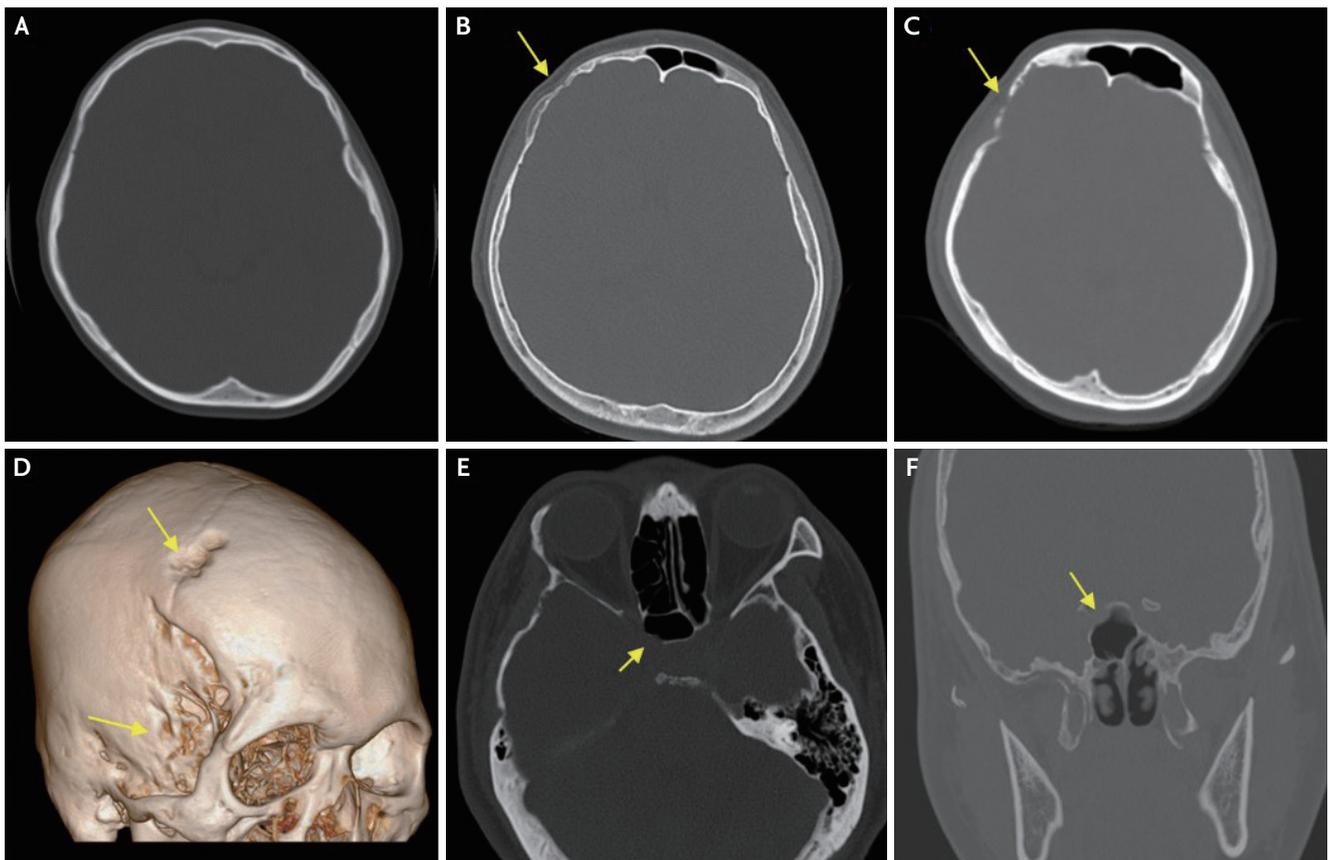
Serial brain CT scan, 3D reconstruction, and OMU CT scan. Serial brain CT scans over a period of more than 10 years revealed progressive cortical thinning of the skull, especially the right frontal bone, right temporal bone and body, and lesser wing and pterygoid plate of the right sphenoid bone. Brain CT performed in 2001 (A) when he fell showed no evidence of cortical thinning, but his CT scan performed in 2007 (B) when he was admitted for bacterial meningitis showed mild erosion of the right frontal bone (yellow arrow). In 2018, the bony destruction had progressed, and extensive cortical thinning (yellow arrow) was identified on a CT scan (C) and the 3D reconstruction of it (D). He underwent an OMU CT for his rhinorrhea, which showed a bony defect (yellow arrow) on the posterior wall of the sphenoid sinus both on axial (E) and coronal reconstruction (F) images. CT; computed tomography, OMU; ostiomeatal unit.
